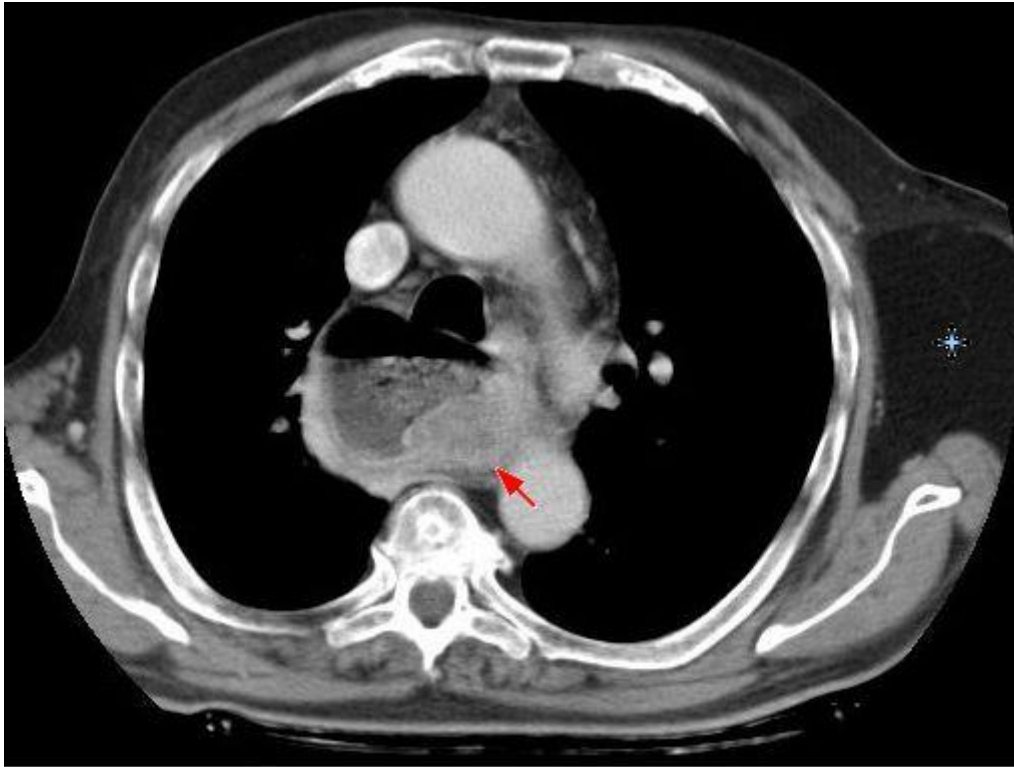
Computed tomography image demonstrating dilated oesophagus with malignant lesion demonstrated by red arrow.
